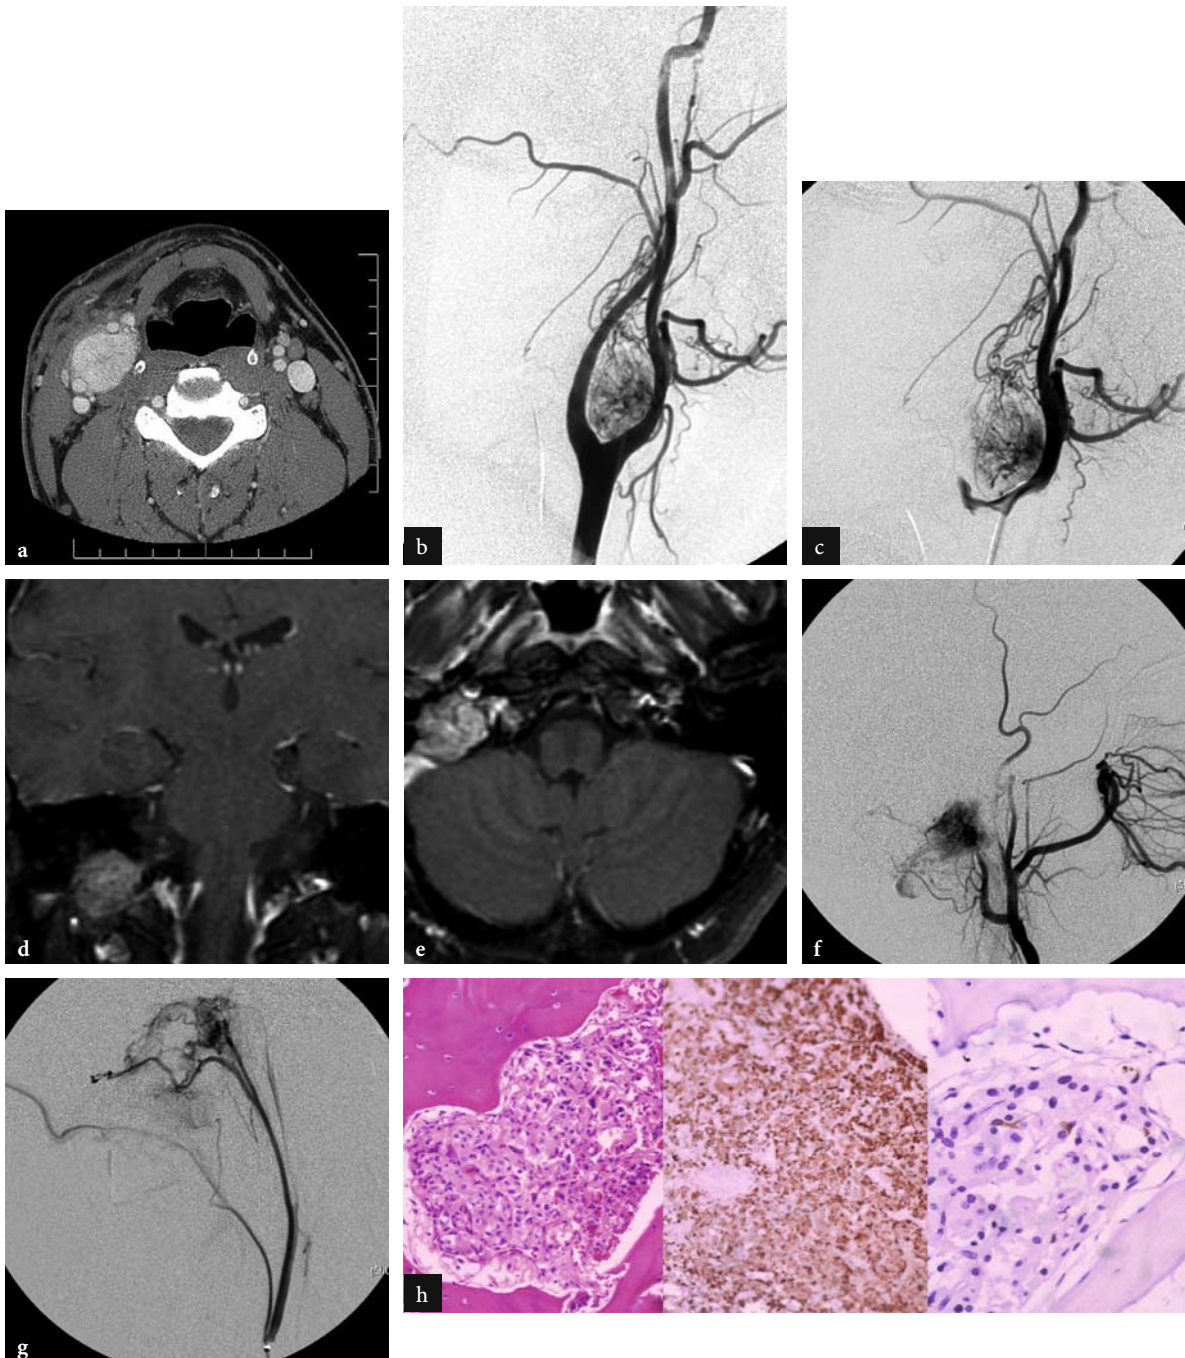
Carotid body tumor (a–c). CT scan a shows the anatomical relationship of the tumor with the carotid artery. Glomus tumor typically shows enhancement after contrast administration. Selective angiography b,c shows tumor blush arising from small ECA branches. Glomus jugulare (d–h) MRI shows the tumor location in relationship with the petrous bone and the jugular bulb d,e. Selective angiography shows tumor blush supplied by the posterior auricular artery (f) and the ascending pharyngeal artery (g). Pathologic examination (h) demonstrates tumor tissue with the typical capsulated structure and epithelial cells surrounded with a vascularized stroma. Courtesy of Dr. K. terBrugge
